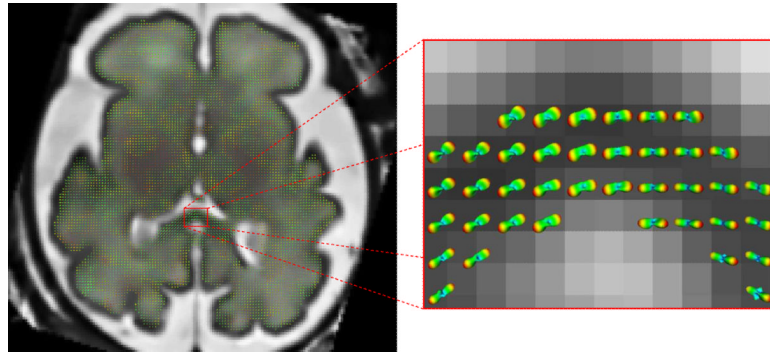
Orientation distribution functions obtained from a reconstructed diffusion-weighted image sequence registered to reconstructed T2-weighted anatomical image.
